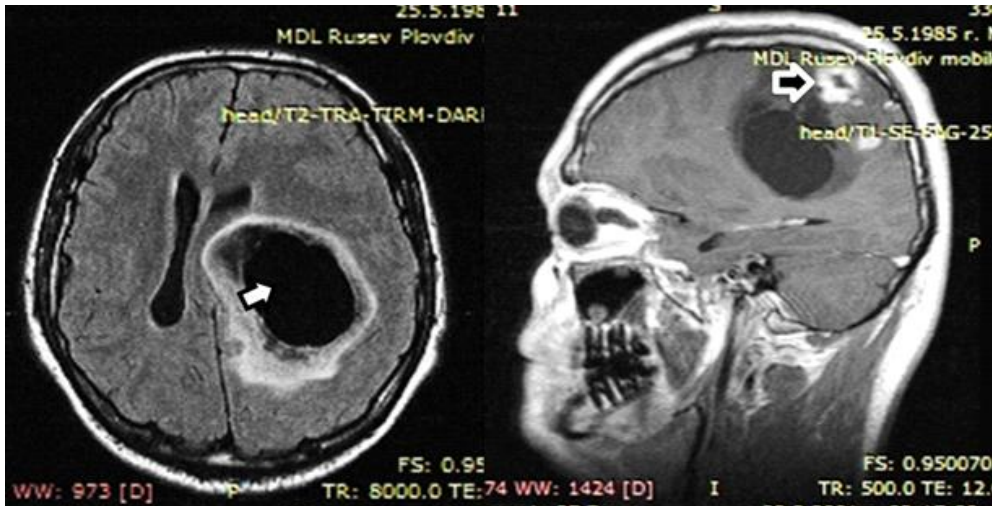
MRI (axial and sagittal projection) of parietal oligodendroglioma: (↔) - cystic part; (↗) - calcification
